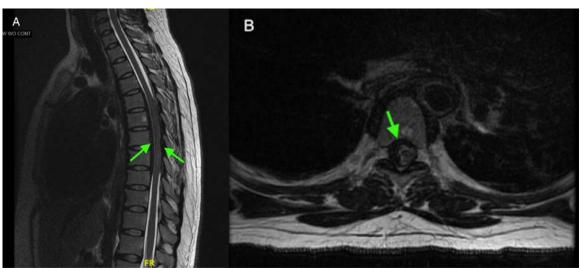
panels A-B. Thoracic spine MRI showing T2 hypointense enhancing soft tissue within the ventral, right lateral, and dorsal epidural space with severe compression and displacement of the thoracic spinal cord to the left with associated mild spinal cord edema (green arrows).
